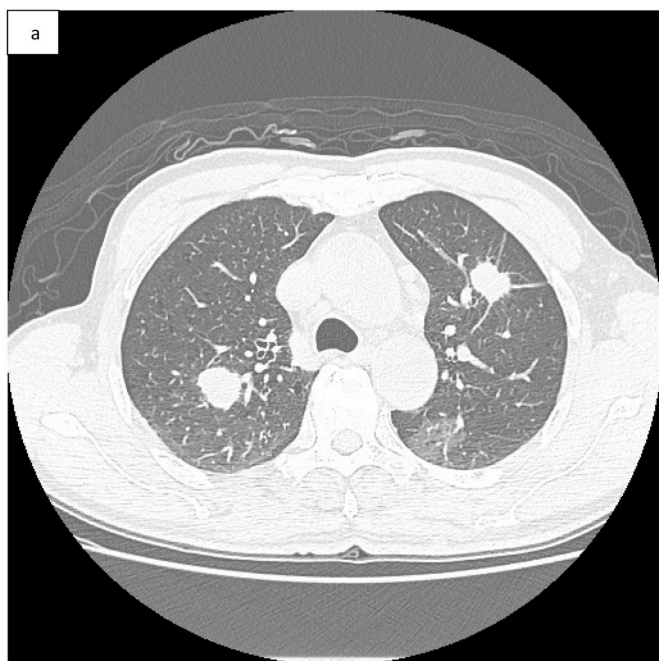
a/1b: Chest CT demonstrated LUL and RUL solid nodules (1a) and LUL and LLL part-solid GGO lesions (1b).
